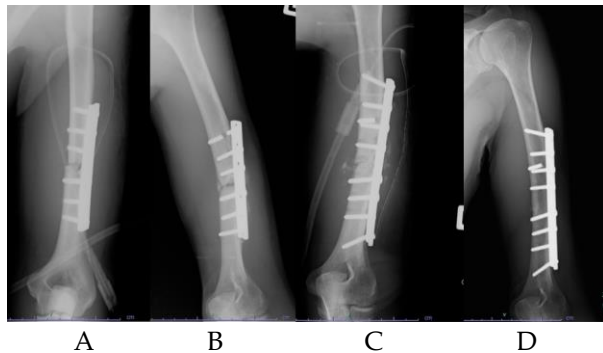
A: Postoperative radiograph after fixation with anterolateral plating. B: Follow-up at 6 months showed nonunion of the fracture and loosening of screws. C: Revised fixation with longer anterolateral plating and an iliac bone graft. D: Follow-up at 6 months showed union of the fracture.
